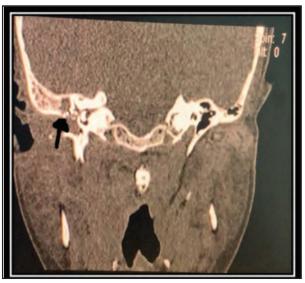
CT scan without contrast Mastoid Axial view showing middle ear opacity over the right side with erosion of posterior EAC wall with extension into mastoid air cells (black arrow)
